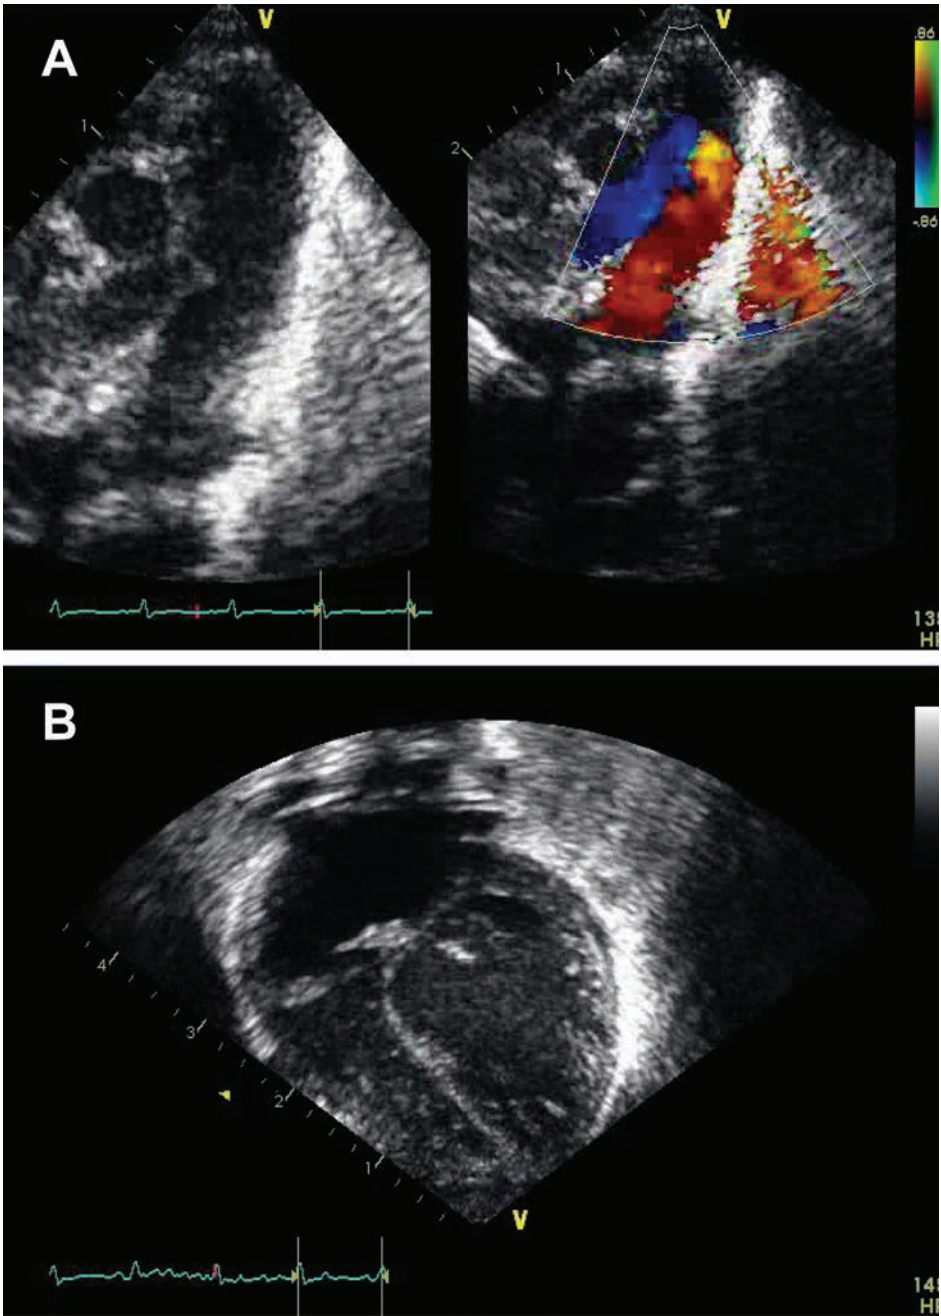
Echocardiographic images of a patient with a large PDA. Panel A shows a short-axis view demonstrating a large PDA with left-to-right shunting. Panel B shows left heart enlargement.
